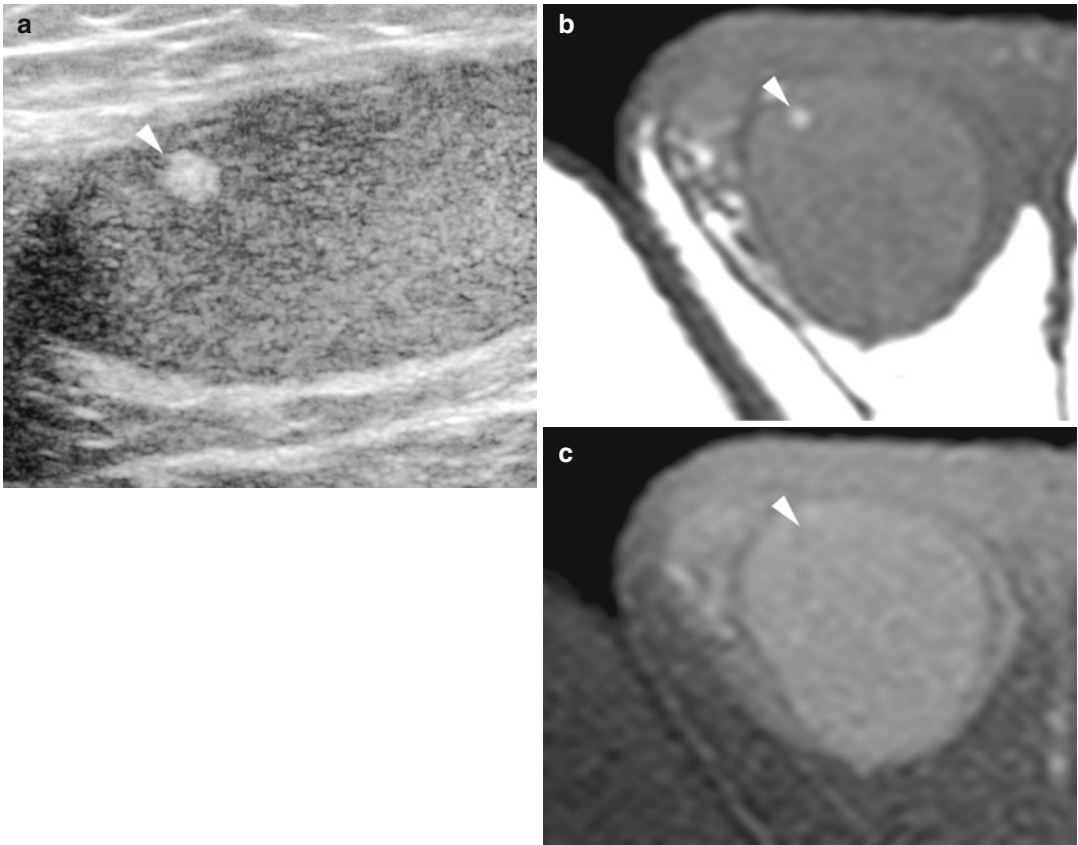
Testicular lipoma. (a) Grayscale ultrasonography shows a small hyperechoic right testicular lesion (arrowhead). (b) The lesion (arrowhead) is hyperintense
